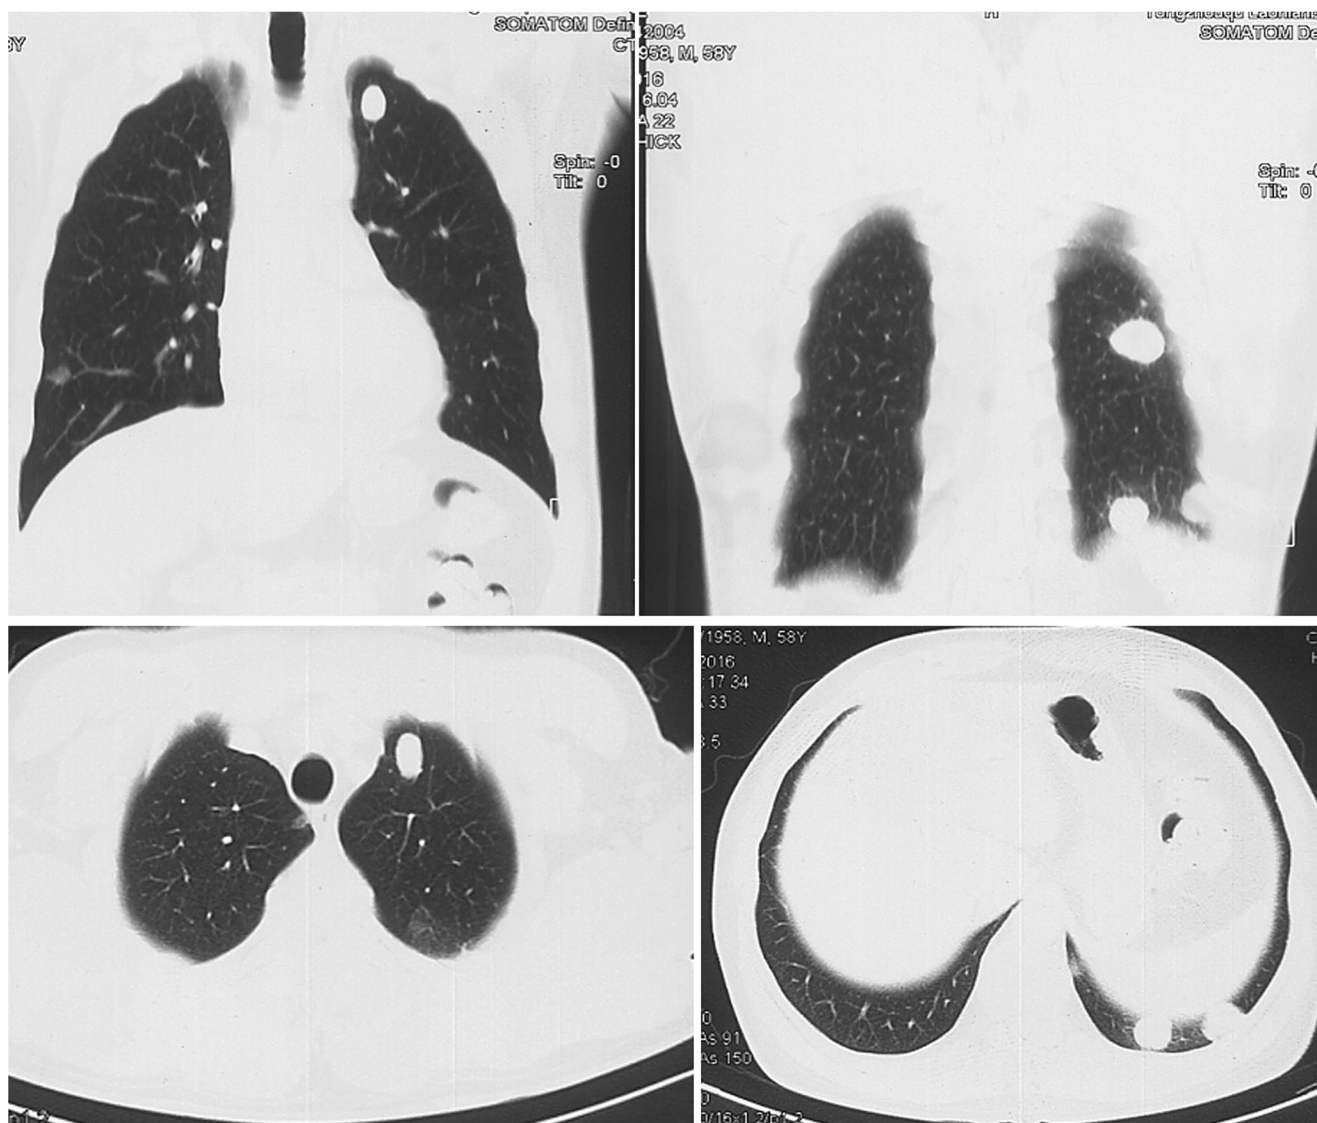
Case-1, a typical patient with multiple metastatic nodules which was shown at coronal and axial CT scans
